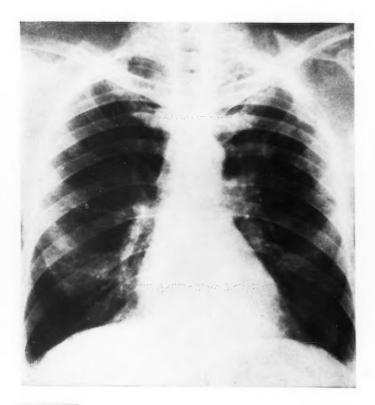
This 45-year-old physician had had a carcinophobia for several years. He was frequently examined. This roentgenogram was properly read: "No pulmonary pathology of present clinical significance." Note the several healed tubercles. Subsequent events showed that even at this time he probably had cancer of the left upper lobe.
